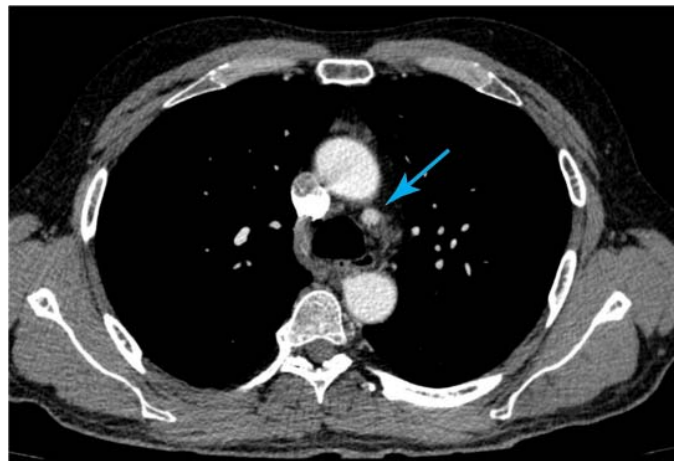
4D CT scan of an adenoma in the aortopulmonary window
